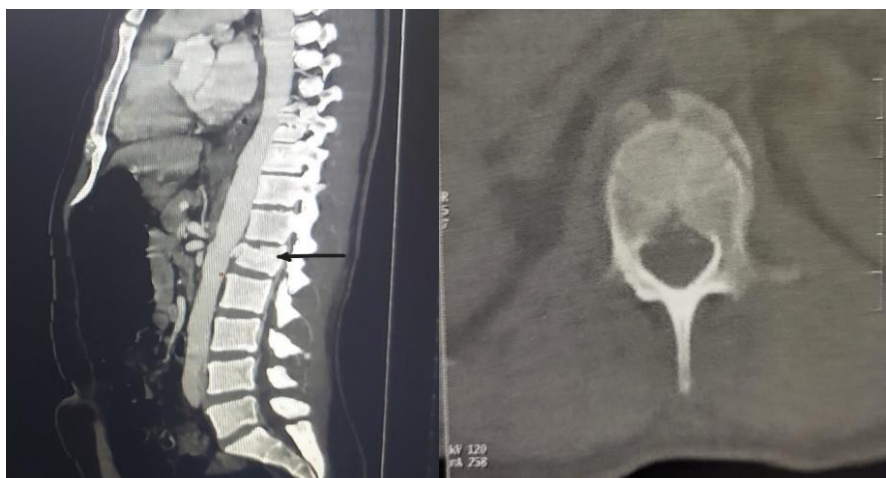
Sagittal CT-scan reconstruction of a horizontal wedge fracture of the upper third of the vertebral body of L1 with detachment of the anterosuperior corner whose inferior edge comes into contact with the sub-renal abdominal aorta
